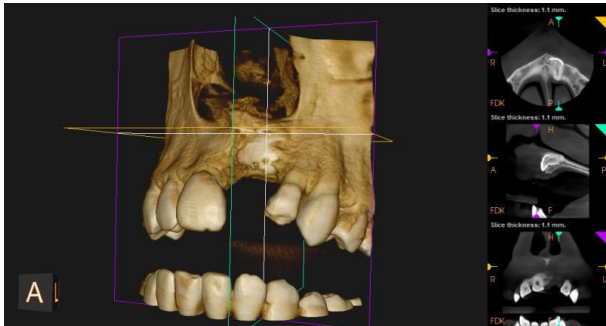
cone beam computed tomography revealing impacted central incisor
